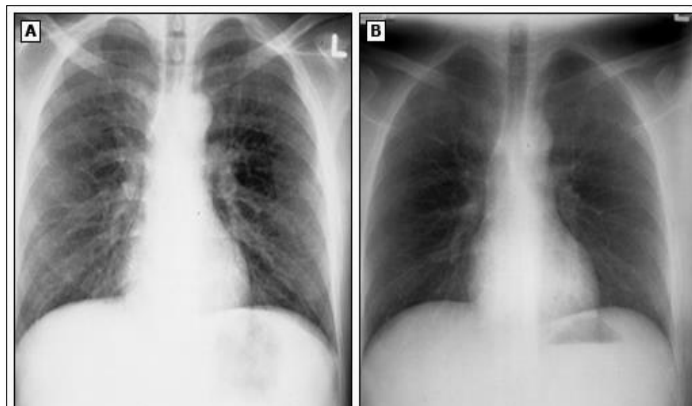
Tropical pulmonary eosinophilia. (A) Chest radiograph of the patient with symptoms suggestive of asthma. (B) Follow-up chest radiograph two weeks after diethylcarbazine therapy.
